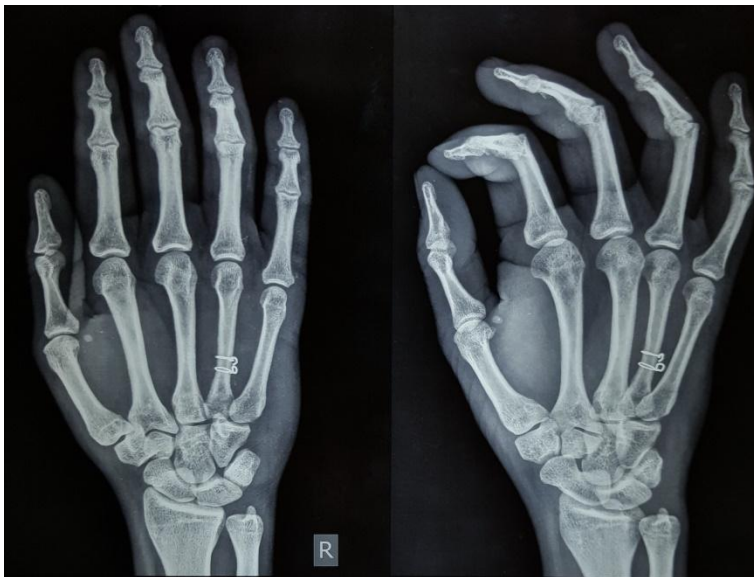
post-op x-ray, note the reduction achieved.
